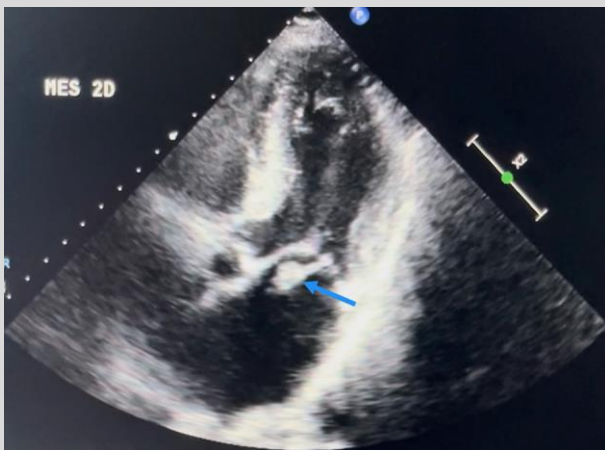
Apical five-chamber view during systole showing mitral valve prolapse with a portion of the ruptured papillary head attached to the anterolateral mitral leaflet (blue arrow).
